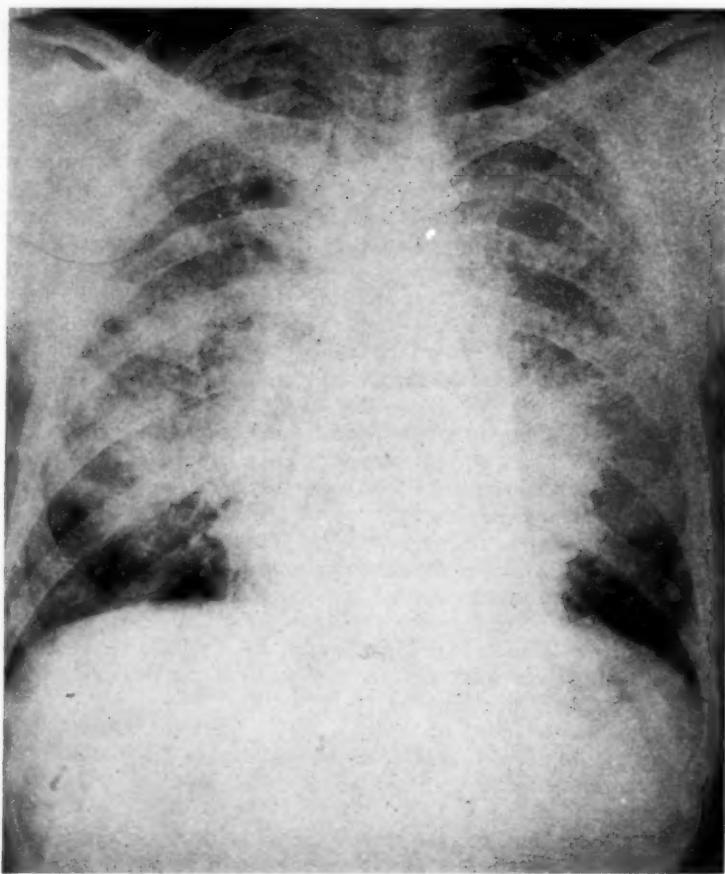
Roentgenogram of the chest of Patient 1, taken on the sixth admission. It is similar to those taken at intervals from the first admission and at times when no acute infection was present.
